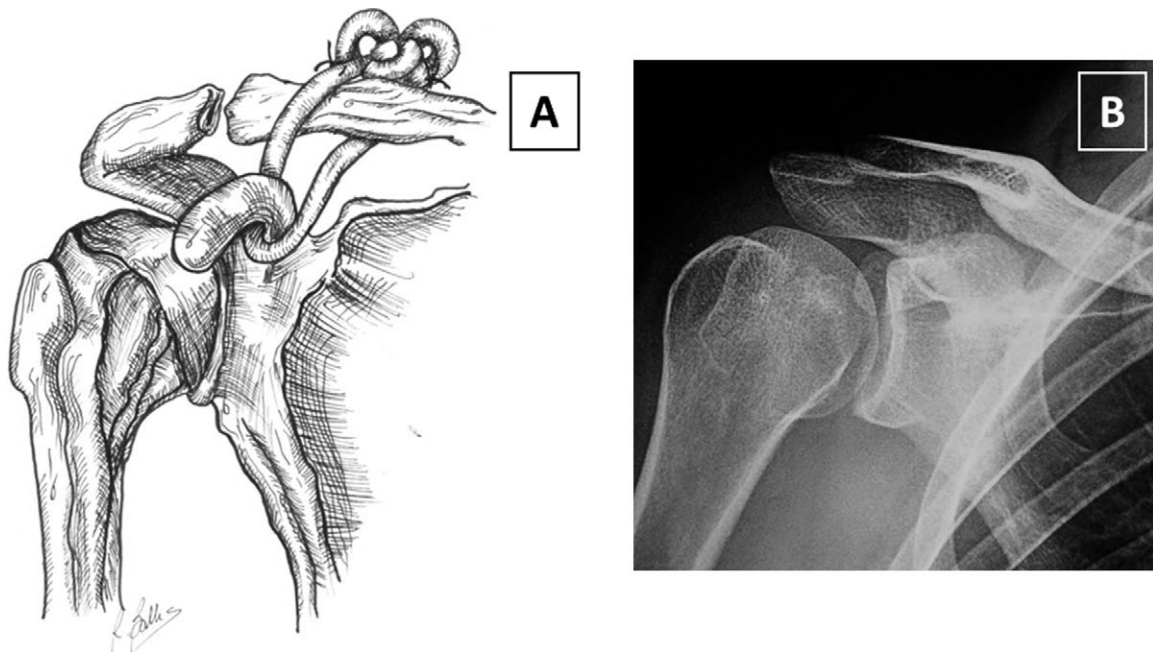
(A) Surgical technique for AC reconstruction with a Dacron vascular prosthesis. With the patient lying in beach-chair position, a 7 cm long epiclavicular skin incision is made from the tip of the acromion to the medial side of the clavicle. After identification of the coracoid process, an acromioclavicular K-wire is placed in order to keep the AC joint stable. The vascular prosthesis is then passed around the coracoid and secured over the clavicle with a knot. (B) X-ray taken 15 months after surgery showing satisfactory reduction of the AC dislocation.
